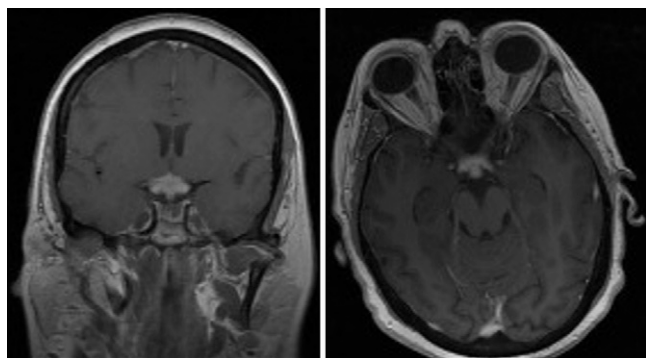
Coronal (left) and axial (right) postcontrast T1-weighted MRI showing mass lesions with homogeneous enhancement of the optic tracts involving the chiasm with slight enhancement of the infundibulum.
